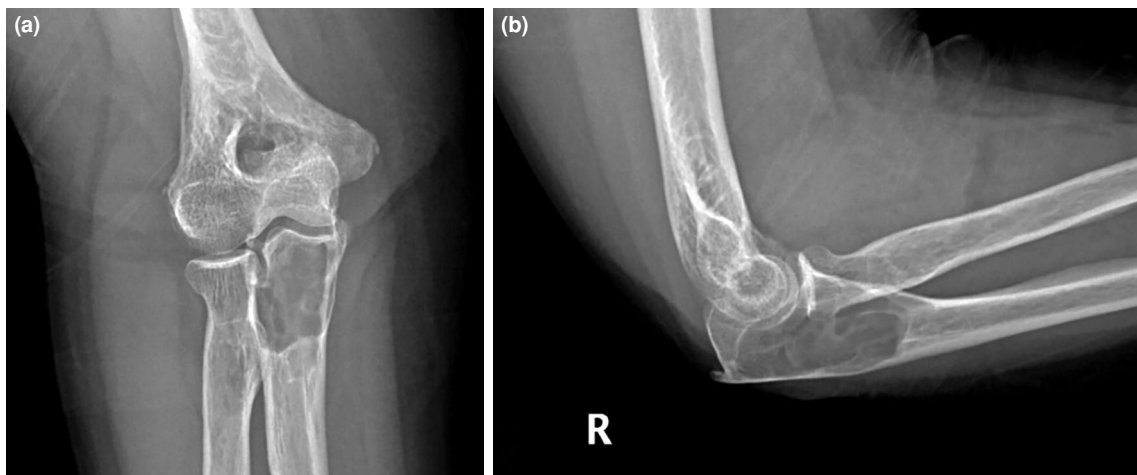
Preoperative X-ray appearance. (a) Anteroposterior X-ray. (b) Lateral X-ray.
